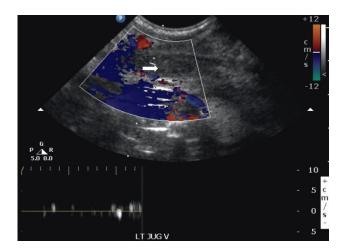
Venous ultrasound of the upper extremity showing occlusive left internal jugular vein thrombosis (thick arrow) and no flow was seen on Doppler study.
